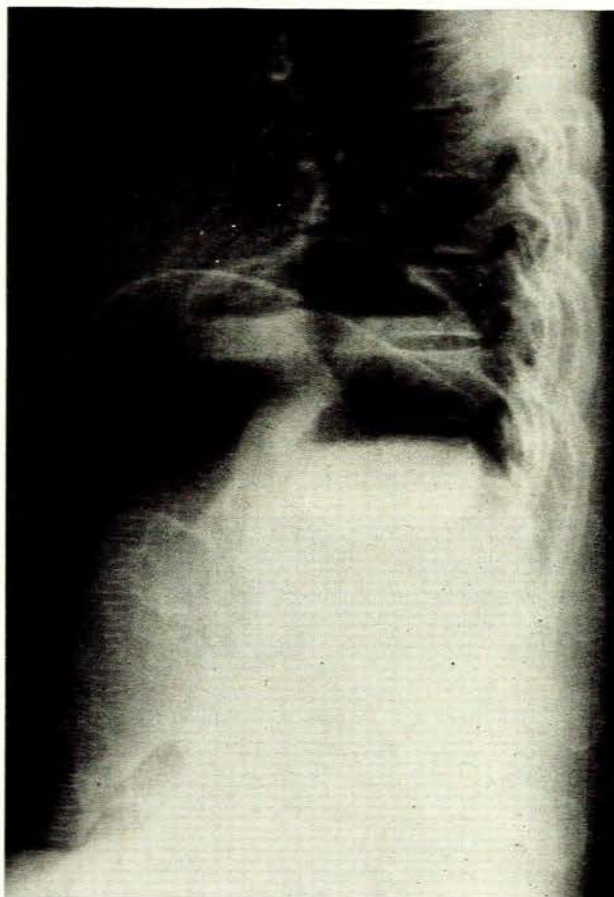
Lateral chest X-ray film after pneumoperitoneum, clearly showing stomach above both diaphragms.
